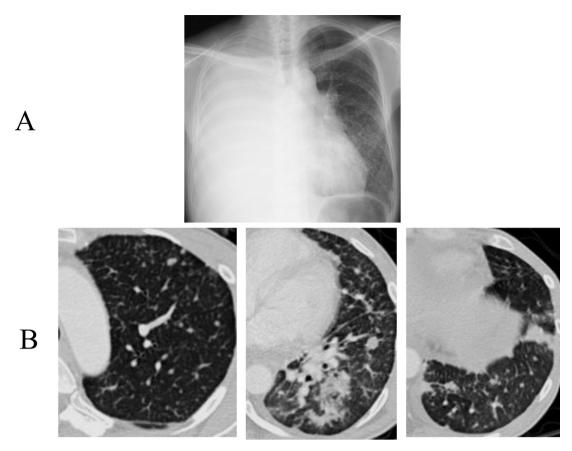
Chest radiograph and CT on admission. (A) Chest radiograph revealed right pleural effusion and multiple nodules in the left lung field. (B) Chest CT demonstrated multiple small nodules and interstitial thickening in perihilar and peribronchovascular distribution.
